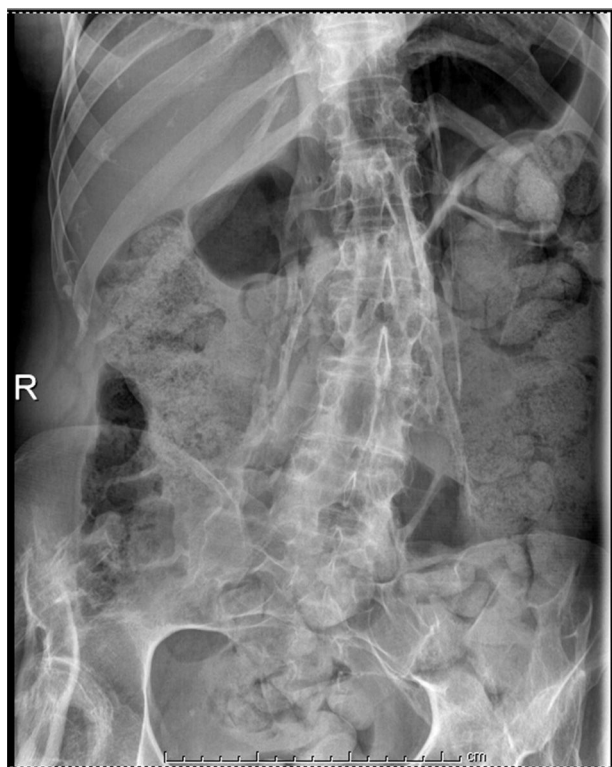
Radiograph of abdomen showing paravertebral bone bridges that are also seen in right hip.
